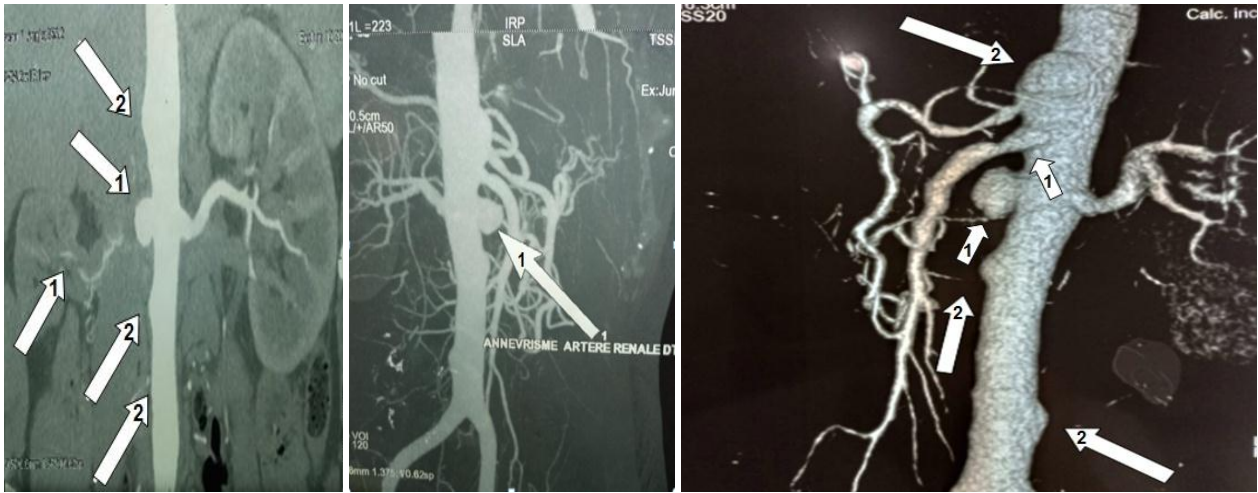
Abdominal CT angiography.
